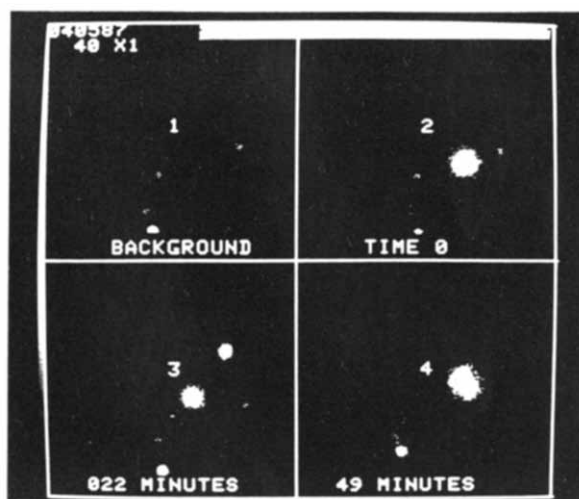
Typical scintigraphic images taken immediately after administering balloon tablets and non-disintegrating tablets, 22 min after and 49 min after, under fasted state.
